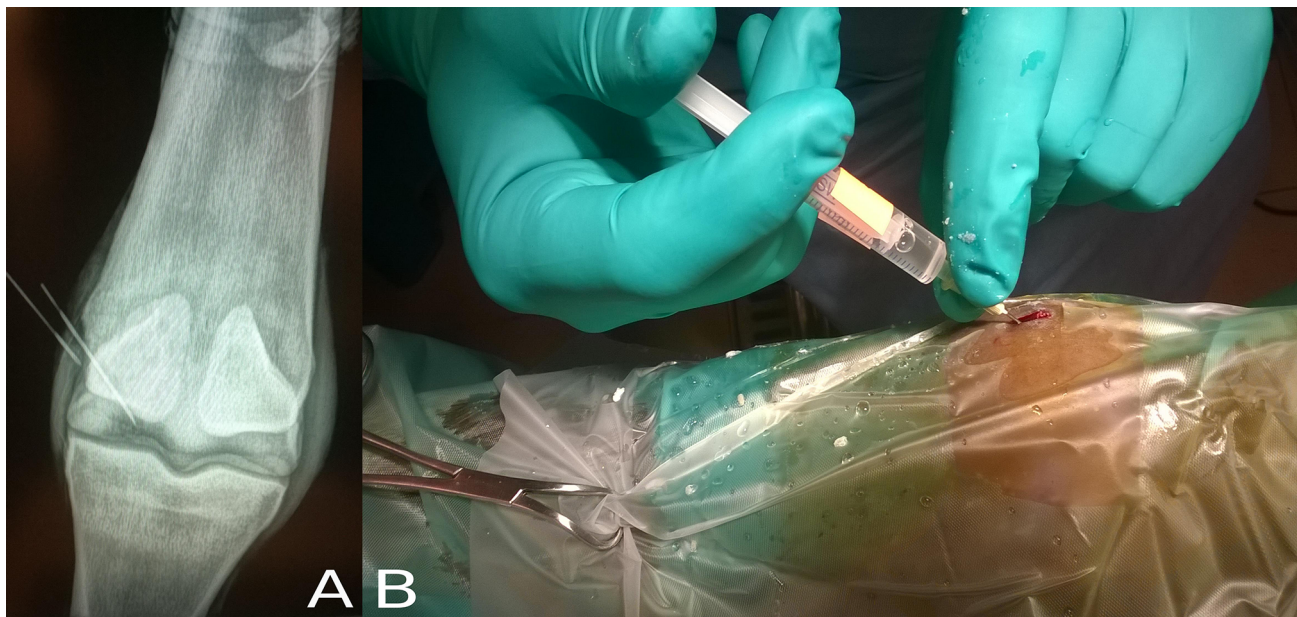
A: Intraoperative control radiograph performed directly after drilling. Note: the needle was placed in the drilling hole for better evaluation. B: Administration of stem cells alginate/ CaCl_2
